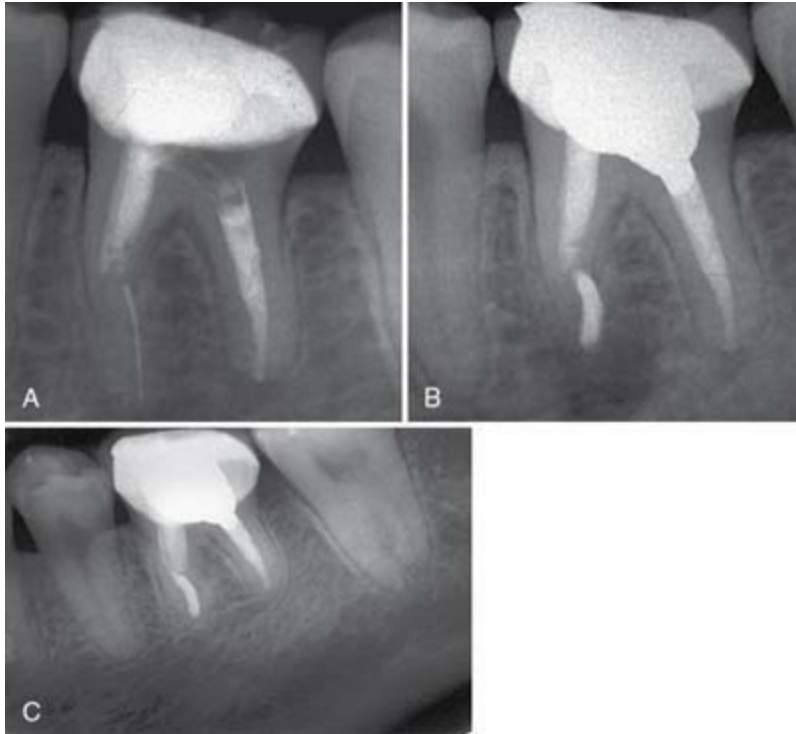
A, Nickel-titanium file broken inside the mesiobuccal canal of the mandibular first molar. B, Due to patient discomfort, the segment was surgically removed and mineral trioxide aggregate (MTA) was used as root-filling material. C, Periapical radiograph 2½ years posttreatment shows complete healing.
